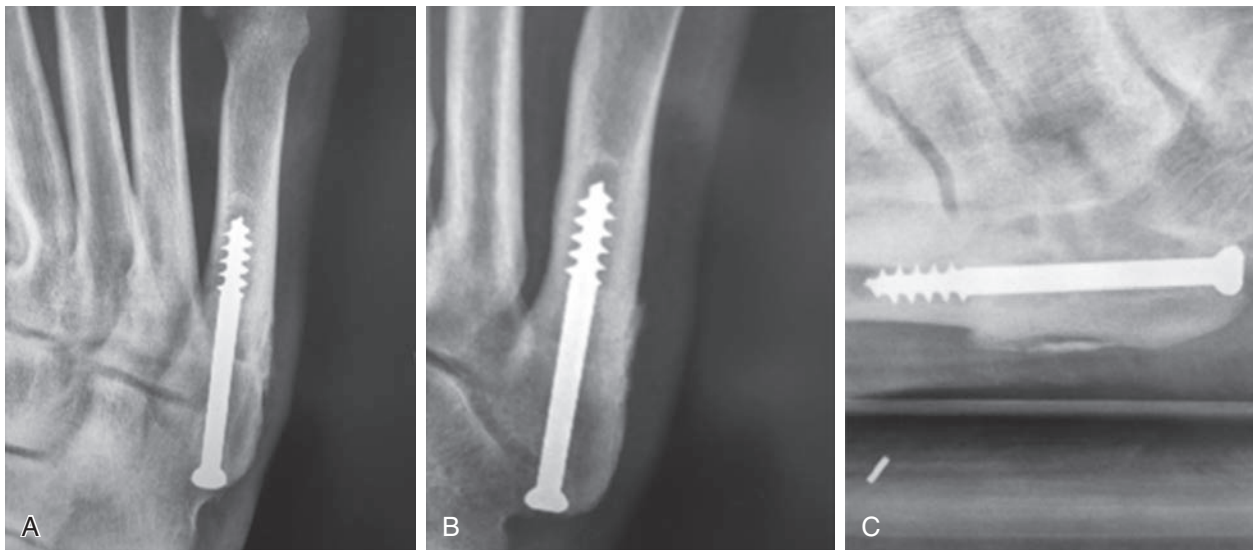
Case 3,1 (A) 5th metatarsal fracture, S/P 3rd ORIF, nonunion, AP View. (B) 5th metatarsal fracture, S/P 3rd ORIF, nonunion, Lateral View. (C) X-ray of right foot.
